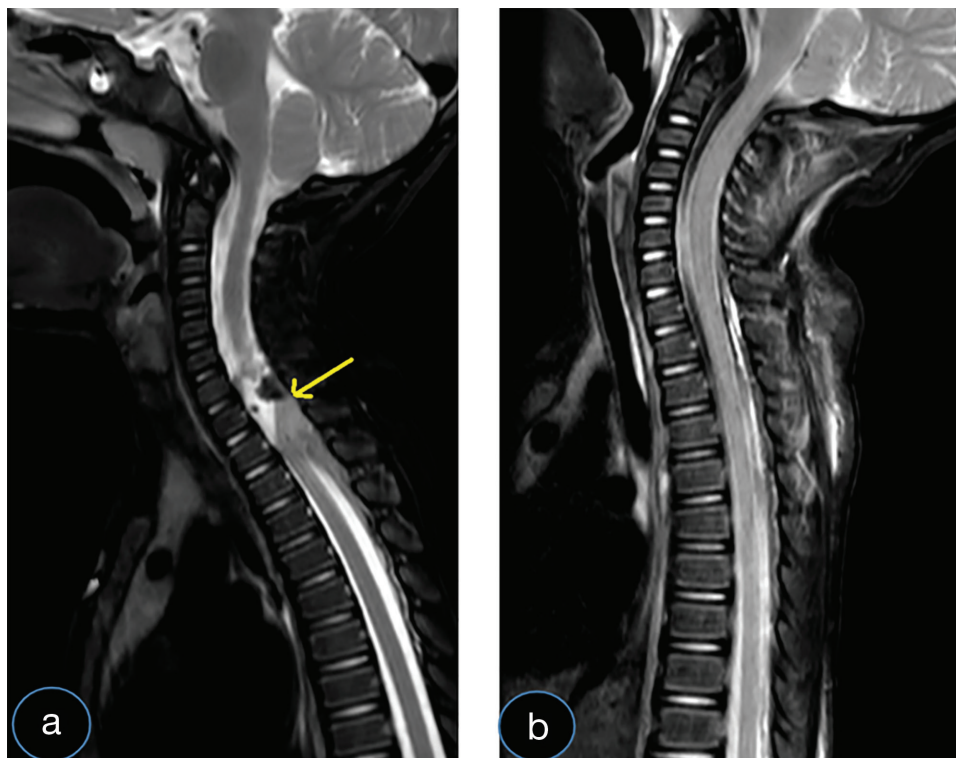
(a) Sagittal T2 weighted images using magnetic resonance imaging (MRI) showing an elongated lesion (yellow arrow) in the dorsal region of the spinal epidural space from the level of C7 to Th4 with compression of the spinal cord without edema pre-operatively. (b) A post-operative MRI scan with contrast showing a complete removal of the lesion 2 months post-surgery.
